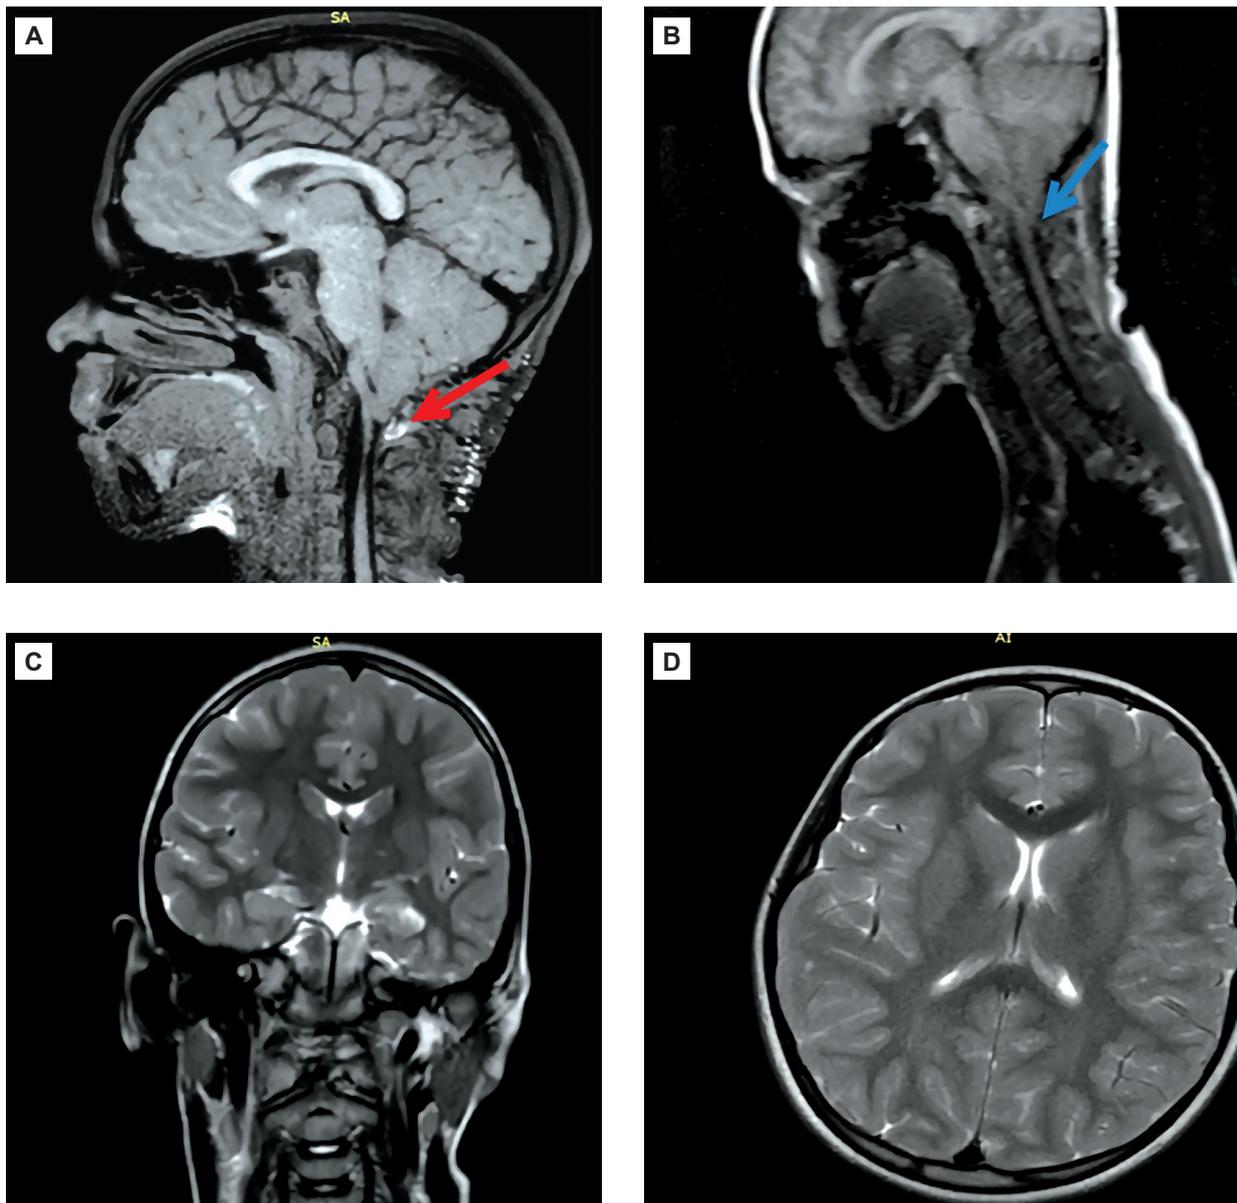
a) Preoperative sagittal image of a brain and cervical spine MRI: decompression of the craniovertebral junction. A descent of the cerebellar tonsils below the foramen magnum. See the red arrow. b) Images of the sub- and supratentorial structures using a series of FLAIR, DWI, SWI, and T1- and T2-weighted brain CT scans. See the blue arrow. c) Coronal image. A postoperative defect of the posterior arch of the C1 vertebra and squamous cell occipital bone is observed, as well as soft tissue edema in the occipital region. d) The cerebellar tonsils and medulla oblongata prolapse into the foramen magnum to the level of the middle third of the C2 vertebra. The midline structures are not displaced, and the cerebral ventricles are normal in shape and size
